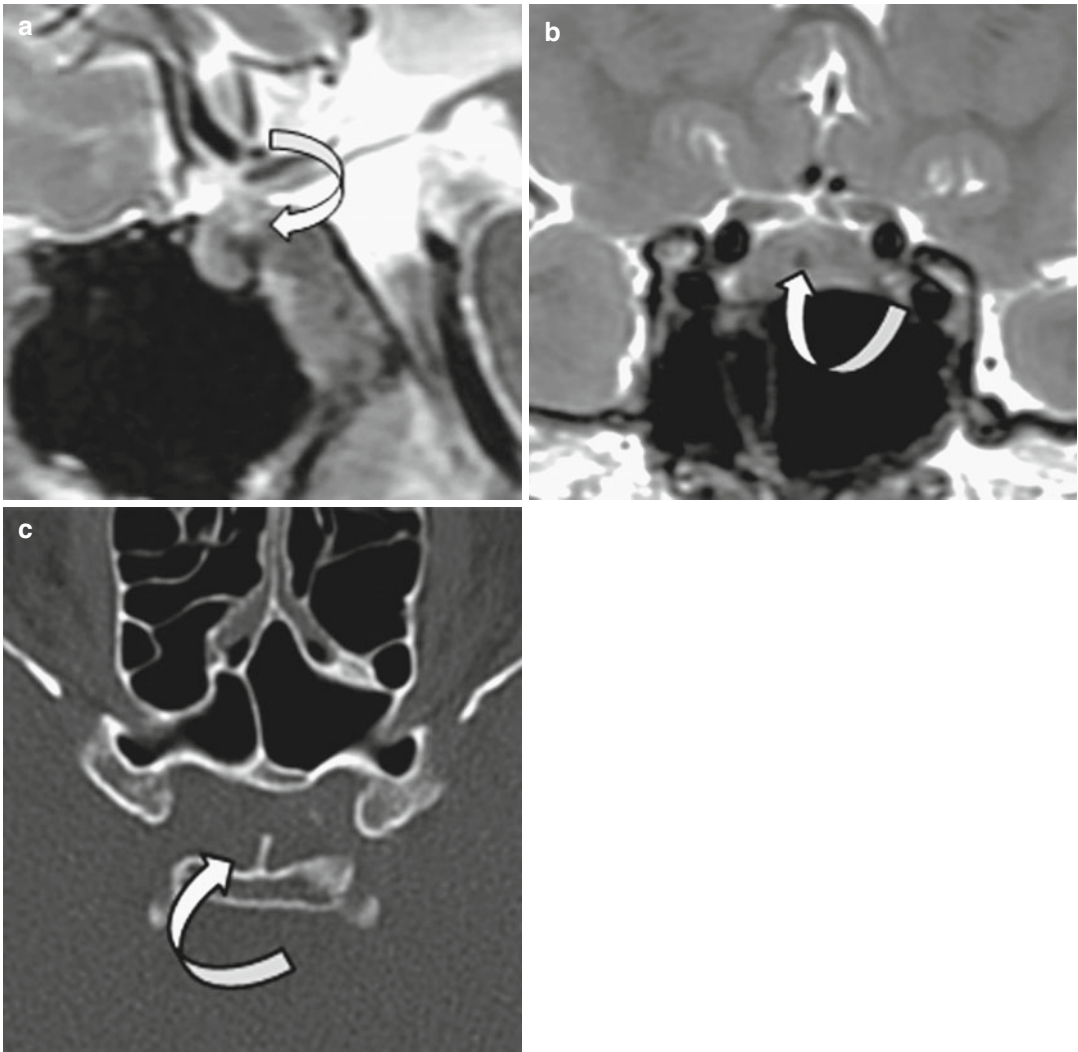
Sellar spine (*arrow*) arising from the dorsum sellae and pushing the pituitary gland upward. (a, b) Sagittal and coronal T2WIs. (c) Axial CT
